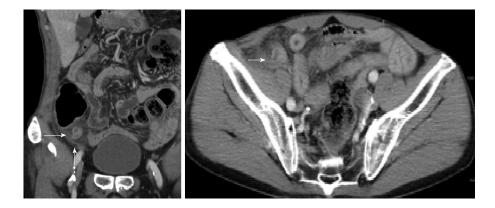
Computed tomography scan showing appendiceal diverticulitis. An oblique coronal reformation of contrast-enhanced CT scan (5-mm thick) showing an inflamed diverticulum (arrow) and stranded surrounding fat. The inflamed diverticulum is visualized as a small, round cyst with an enhancing wall attached to the distal segment of the appendix. However, this patient's appendix was not filled with fluid or enlarged.
